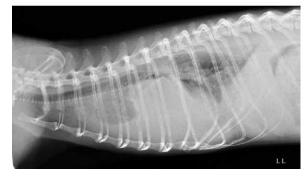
Dorsoventral (DV) and lateral (LL) radiographs of a 6-year-old male ferret with a liquothorax due to severe cardiac failure.
